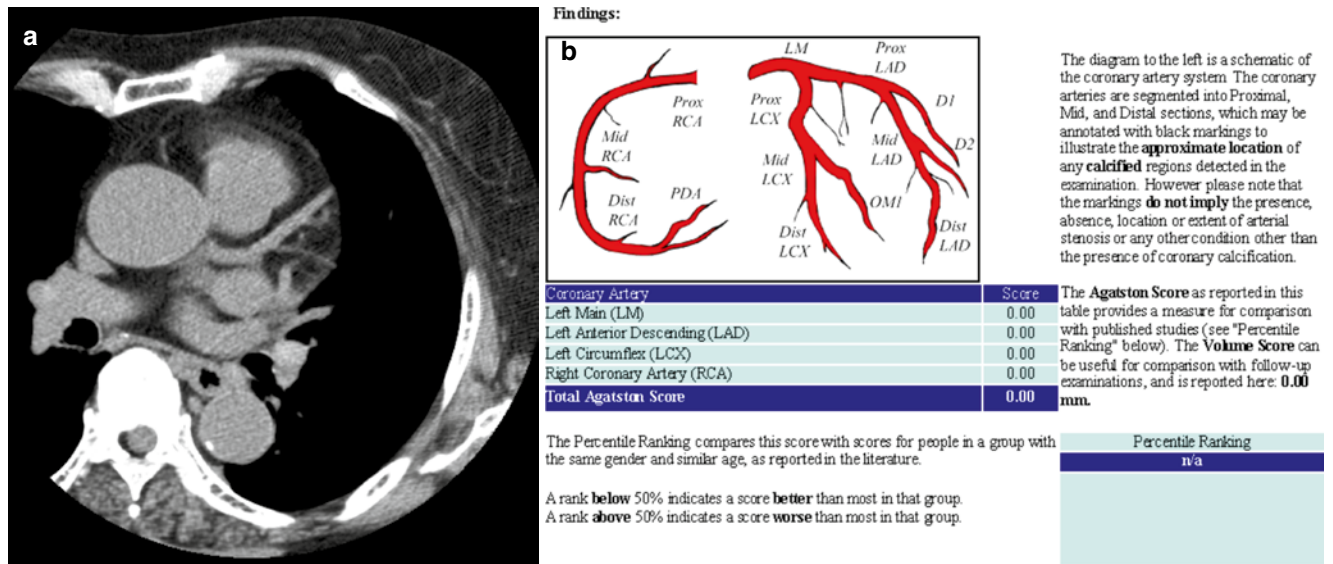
A 72-year-old female. (a) Non-enhanced axial CT for calcium scoring shows no calcium in the coronary arteries. Small nodular calcification is noted in the descending aortic wall. (b) Total Agatston score is zero (From Hoff et al. [9])
